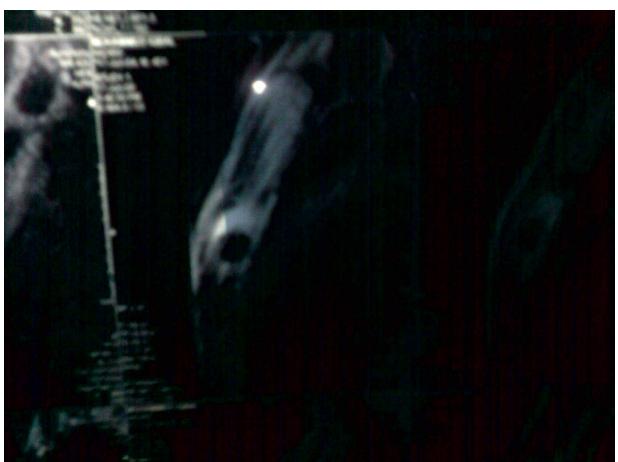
Radiological involvement of the manubriosternal joint on MRI
